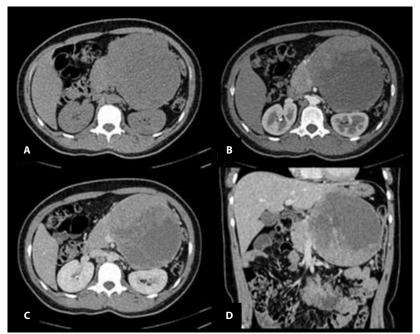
Multiphase helical CT of the abdomen with intravenous contrast. Axial (A-C) and coronal (D) slices in simple (A), arterial (B) and portal venous (C,D) phases
